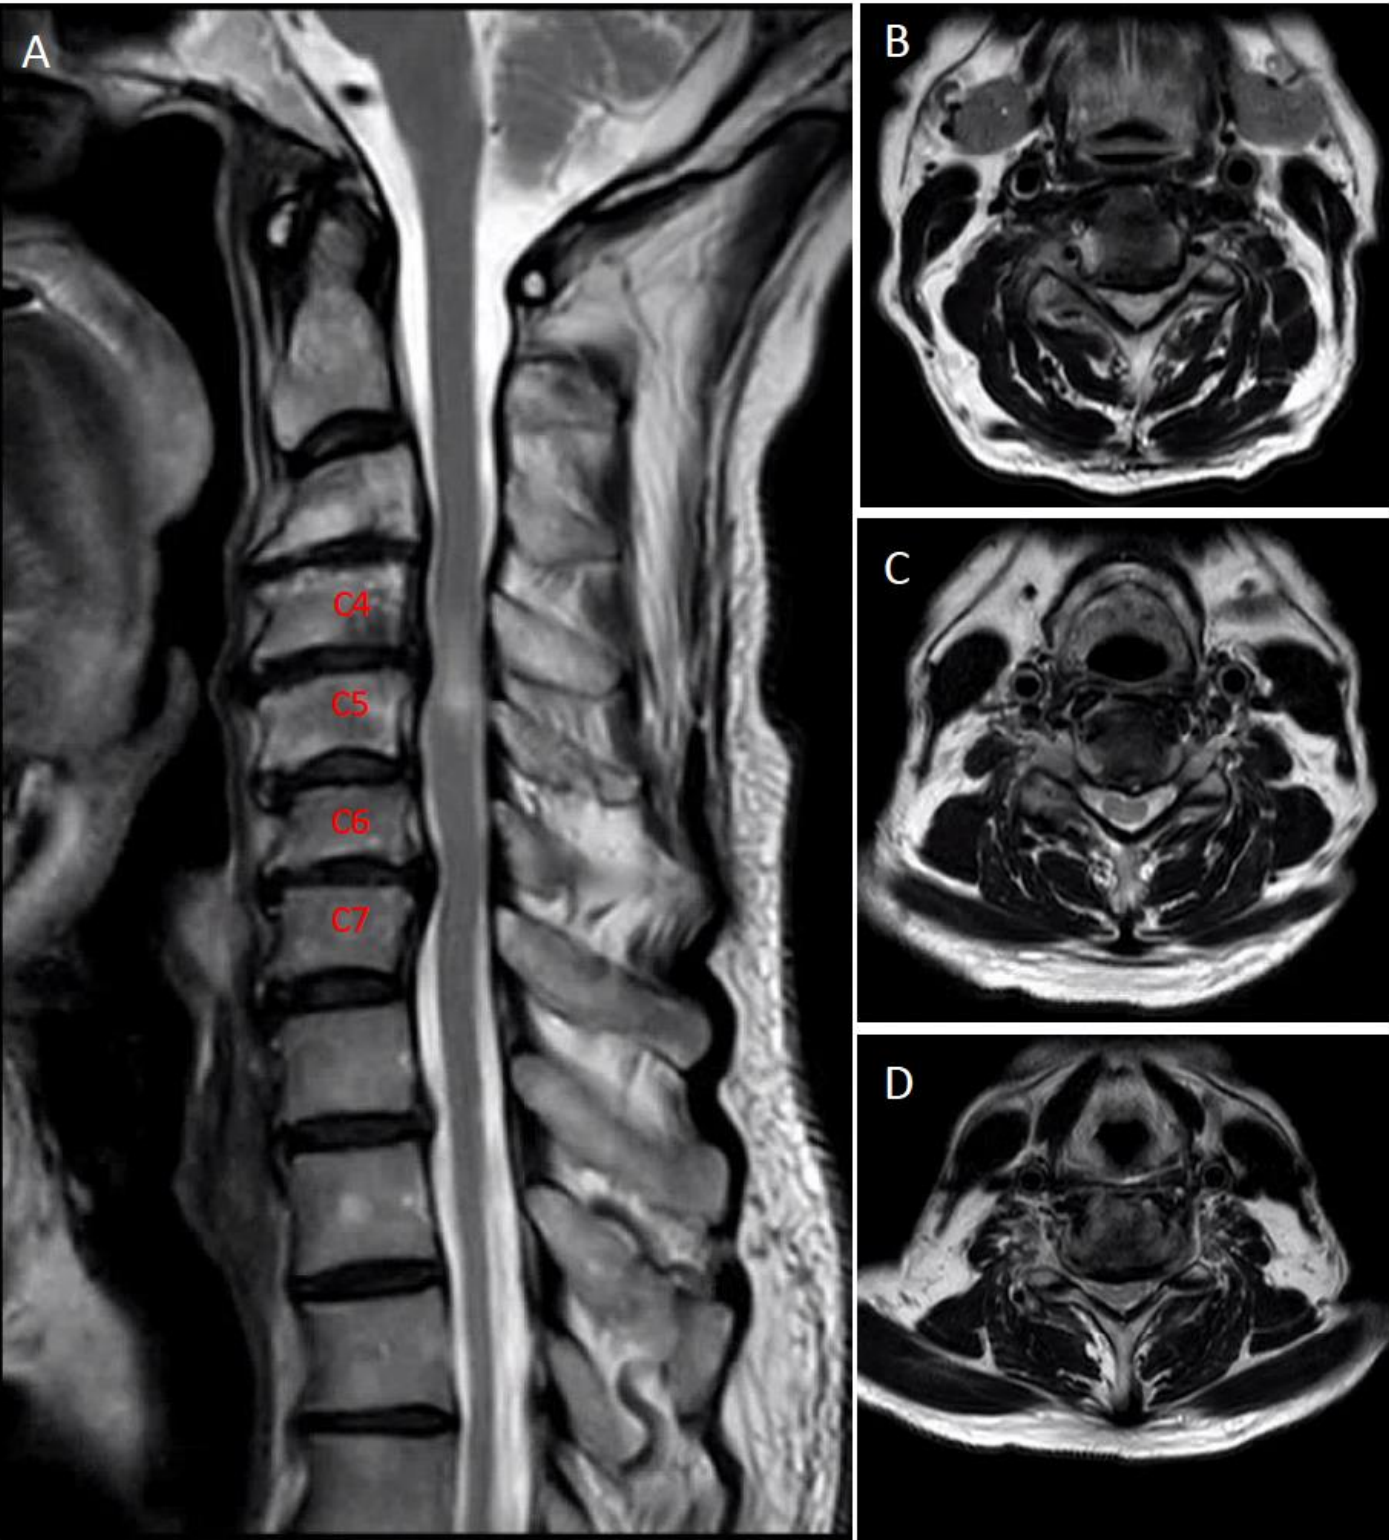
Preoperative MRI of the cervical spine demonstrating multilevel degenerative pathology. Sagittal T2-weighted imaging (A) shows severe canal stenosis from C4 to C7 with associated cord signal change. Axial images (B–D) show compressive pathology at the C4–5, C5–6, and C6–7 levels.
